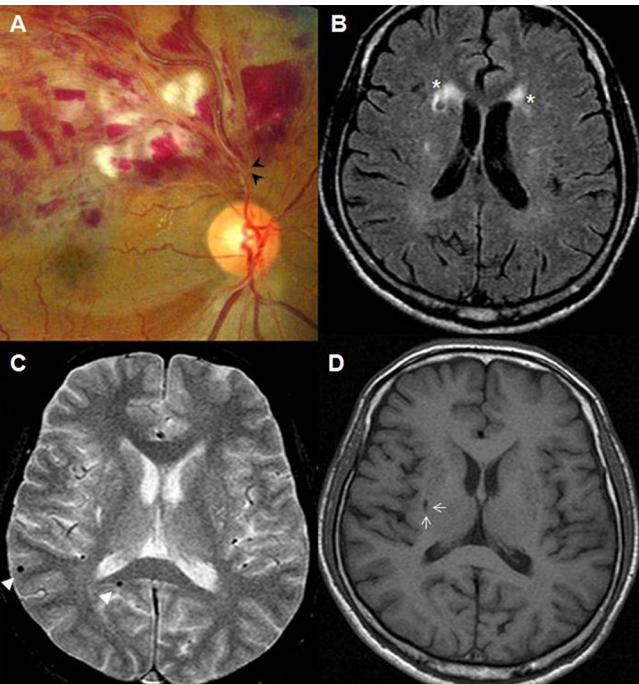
Cerebral small vessel disease in young patient with RVO. (A) Branch RVO with flame-shaped retinal hemorrhage and cotton wool spot in a 56-year-old man. Arteriovenous nicking is shown in the proximal portion of the retinal hemorrhage (*black arrowhead*). (B) White matter hyperintensities (Fazekas grade 2) on brain MRI (FLAIR image; *white asterisks*). (C) Multiple cerebral microbleeds on T2-weighted brain MRI (*white arrowhead*). (D) Silent lacunar infarct in a T1-weighted MRI (*white arrow*) corresponding to cerebral small vessel disease.
